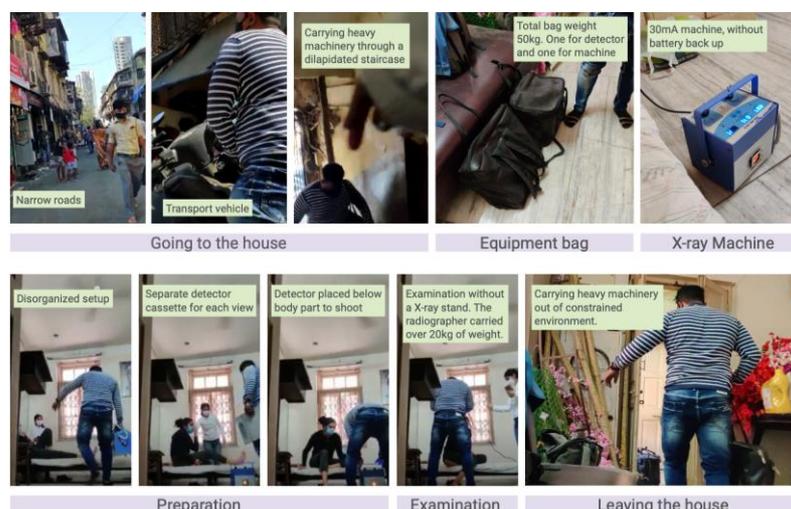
Bodystorming for home X-rays
